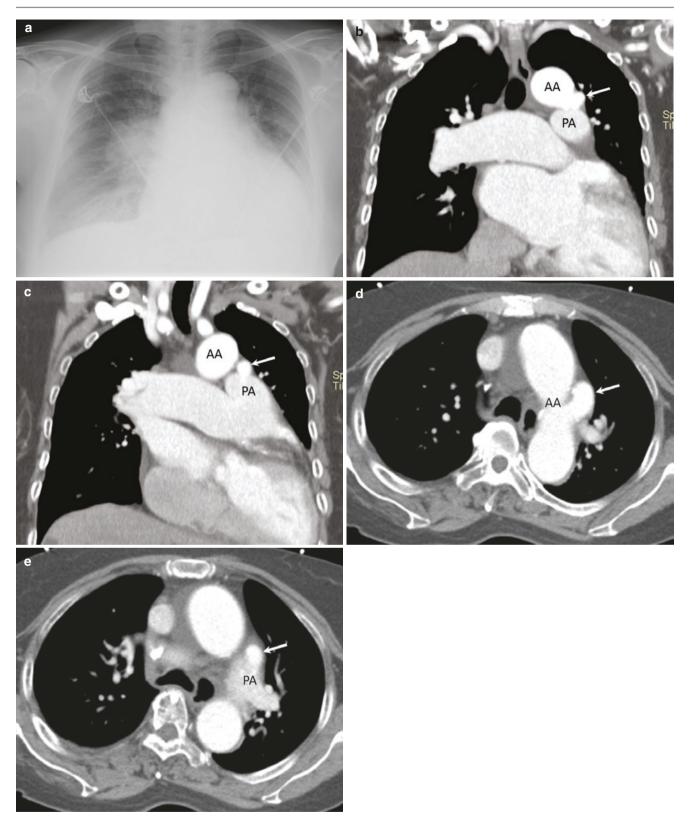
A 68-year-old woman with PAH from patent ductus arteriosus (PDA). (a) Chest radiograph shows markedly dilated central pulmonary arteries. (b–e) Coronal and axial CT aortogram images show a
